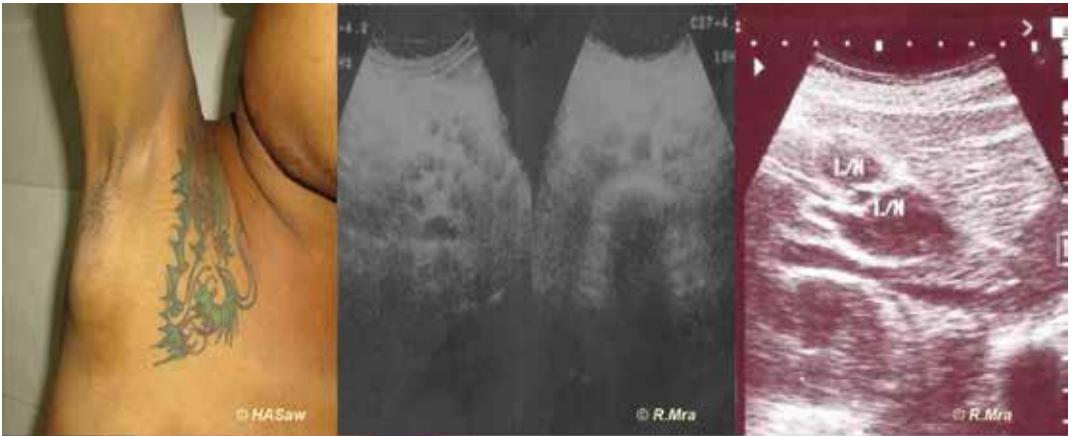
13 - above). Intra-abdominal lymphadenopathy seen as hypoechoic areas on abdominal ultrasound examination. This is most commonly due to tuberculosis with advanced immunosuppression.
